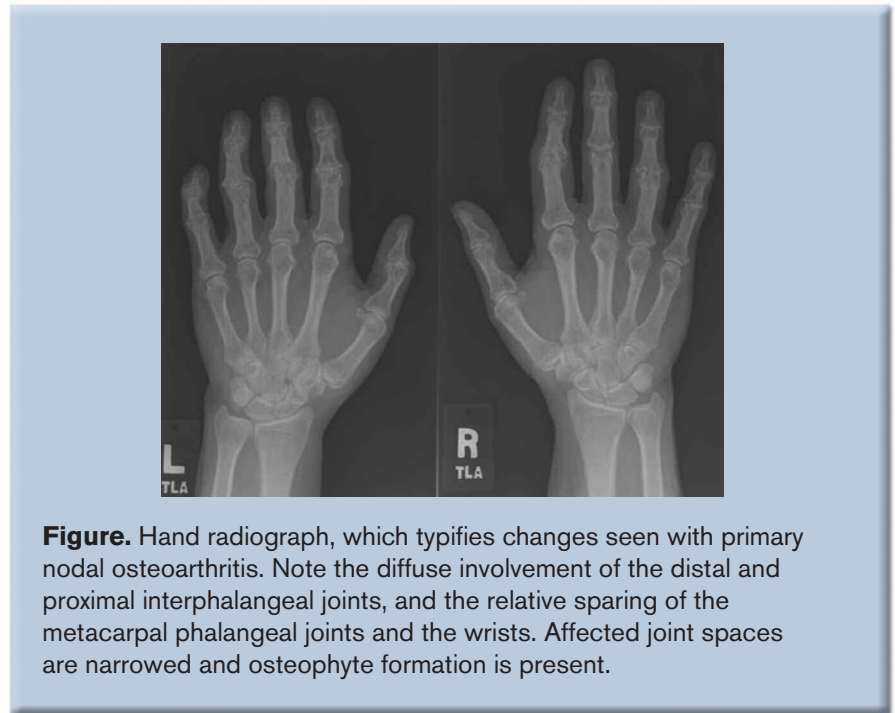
Hand radiograph, which typifies changes seen with primary nodal osteoarthritis. Note the diffuse involvement of the distal and proximal interphalangeal joints, and the relative sparing of the metacarpal phalangeal joints and the wrists. Affected joint spaces are narrowed and osteophyte formation is present.
